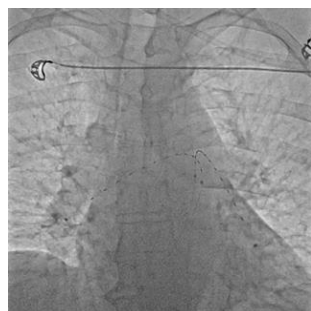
Ultrasound-assisted thrombolysis catheters (EKOS: Boston Scientific, Marlborough, MA, USA) positioned in the right and left pulmonary arteries.
